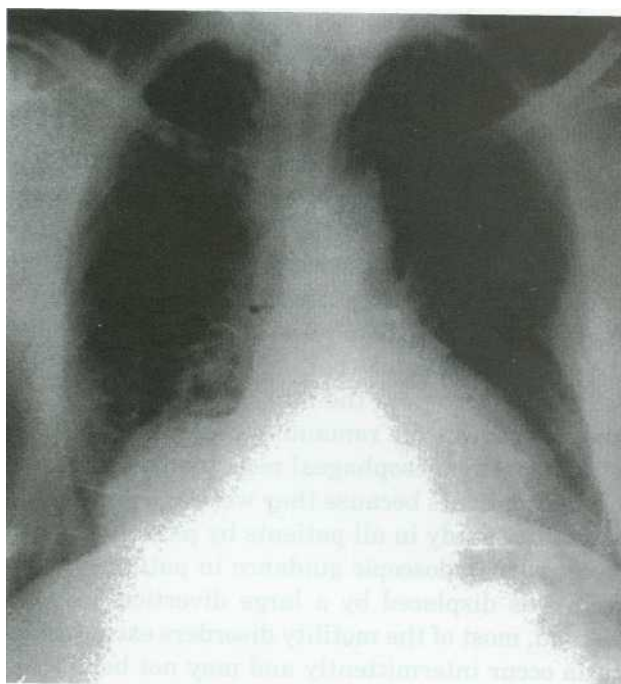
Chest X-ray: Right paracardiac mass lesion is seen
